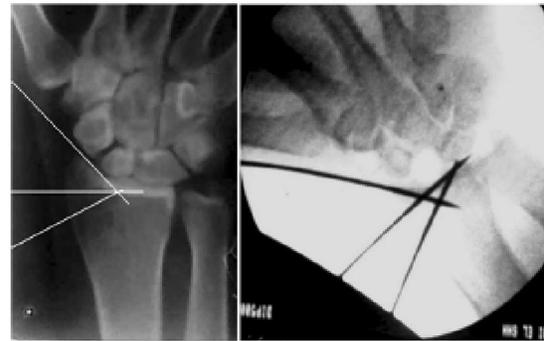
preoperative AP radiographFigure 2: preoperative MRIFigure 3: longitudinal incision centered over the radial styloidFigure 4: Three K wires are inserted to determine the osteotomy borders
